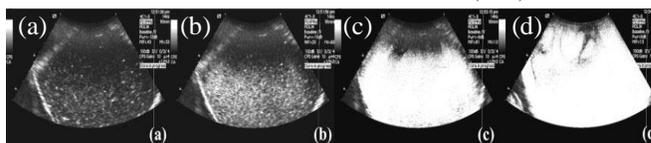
Ultrasound images of OTES-TSPA-TEOS capsules. The gain was kept at 10dB with increasing MI, MI = (a) 0.53, b) 0.73, c) 0.9, and d) 1.5.
